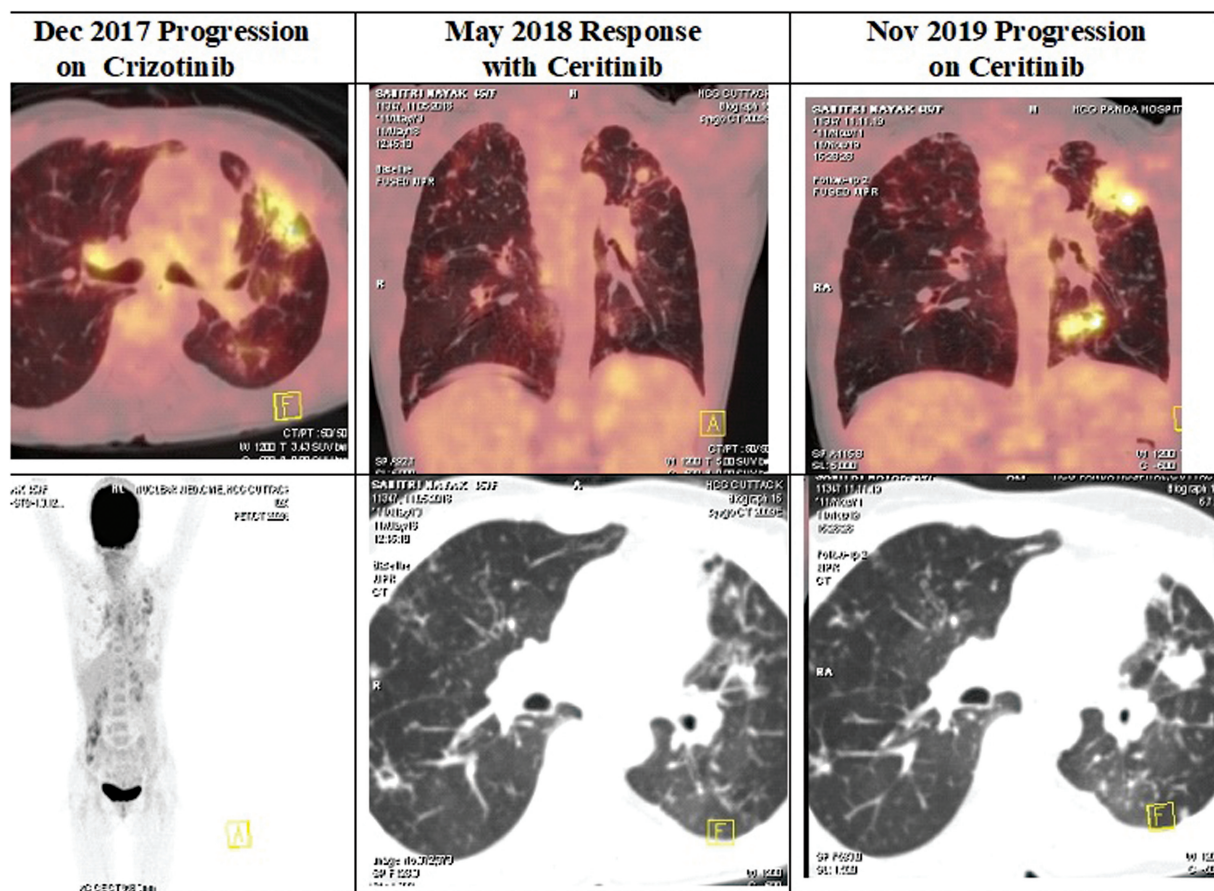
Positron emission tomography-computed tomography (PET-CT) results indicating disease progression (follow-up duration: 26 months).
